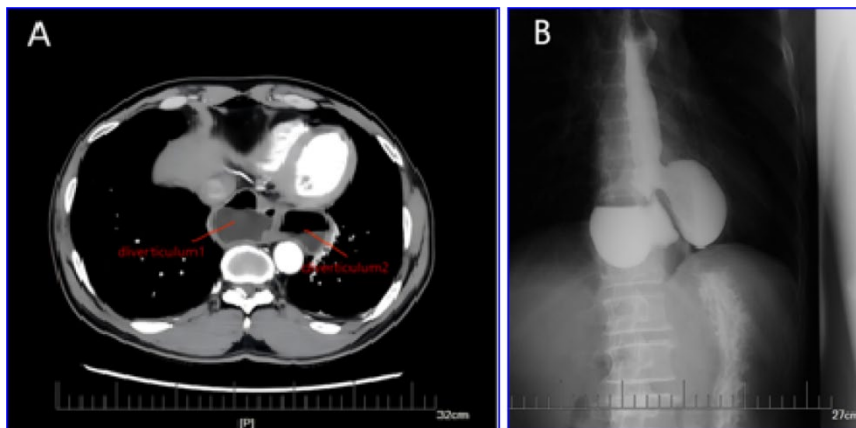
(A) CT and angiography; (B) showed multiple giant diverticula in the lower oesophagus, measuring about 69 x 73 mm and 50 x 37 mm respectively.
